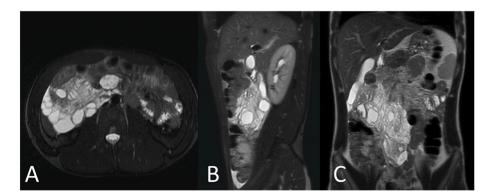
MRI aspect of 15-year-old boy's lymphangioma in trasverse view (A); sagittal view (B); coronal view (C).
